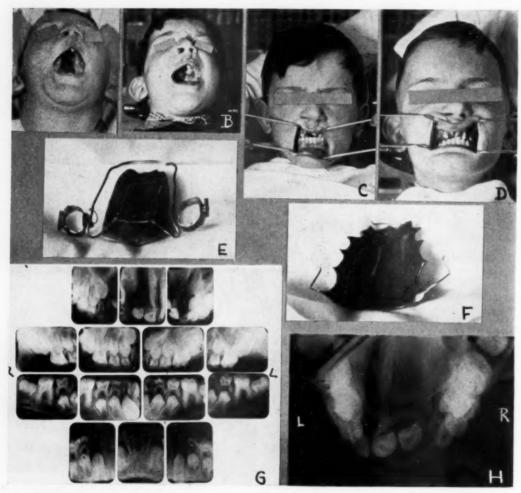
A, Cleft of hard and soft palates before operation. (Courtesy of Carl G. Burdick, M.D.) B, Cleft soft palate closed by operation. Hard palate still to be repaired. C, Teeth in occlusion before treatment. Note position of left central which is visible, while right central is horizontal and not visible. D, Teeth in occlusion after treatment. E, Original appliance used. F, Obturator with clasps to engage buccal tubes on molar bands. G, Full mouth x-ray series. H, Occlusal x-ray reveals bilateral cleft involving both sides of the nasal fossae.
